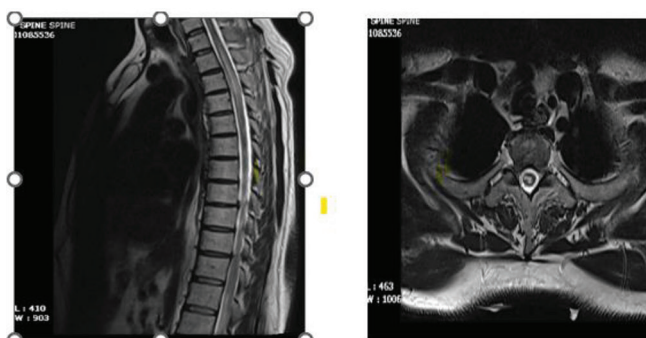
(A) Magnetic resonance imaging (MRI) of Dorsal spine and screening of whole spine axial section, (B) Centro medullary hyperintensities MRI spine sagittal section.
